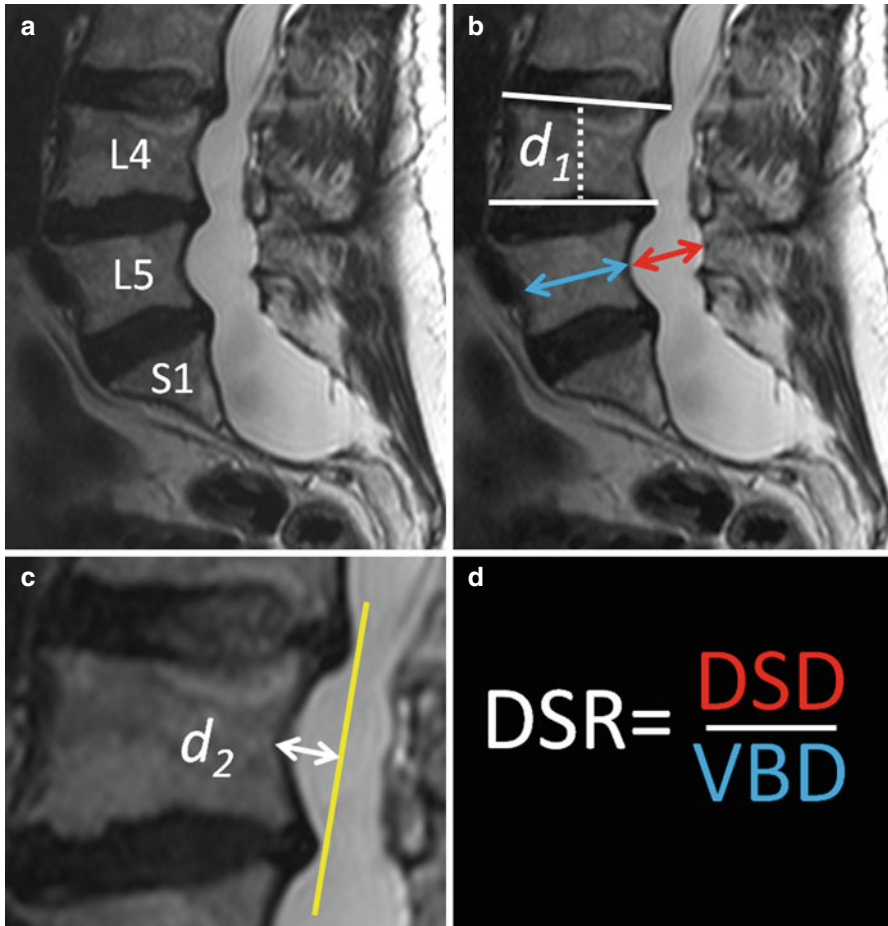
Quantitative radiological assessment of DE. (a) Sagittal T2-weighted MRI acquired from a patient with DE, centred on L4, L5 and S1. (b) White lines drawn through the plane of the superior and inferior endplates of the vertebral body of L4. The perpendicular distance between them (d_1) is a measurement of the vertebral body height and the mid-point of this line ($d_1/2$) is nominated at the level at which to measure corresponding axial metrics such as dural sac diameter (DSD, red arrow) and vertebral body diameter (VBD) and to assess for scalloping. Dural sac ratio can be determined at each level using equation D. (c) Assessment of scalloping. Posterior vertebral margin drawn for L4 (yellow line). The distance in mm (d_2) between this line and the posterior margin of the vertebral body through the plane of the mid-point of the body is measured. A value of d_2 greater than 2 mm suggests scalloping
